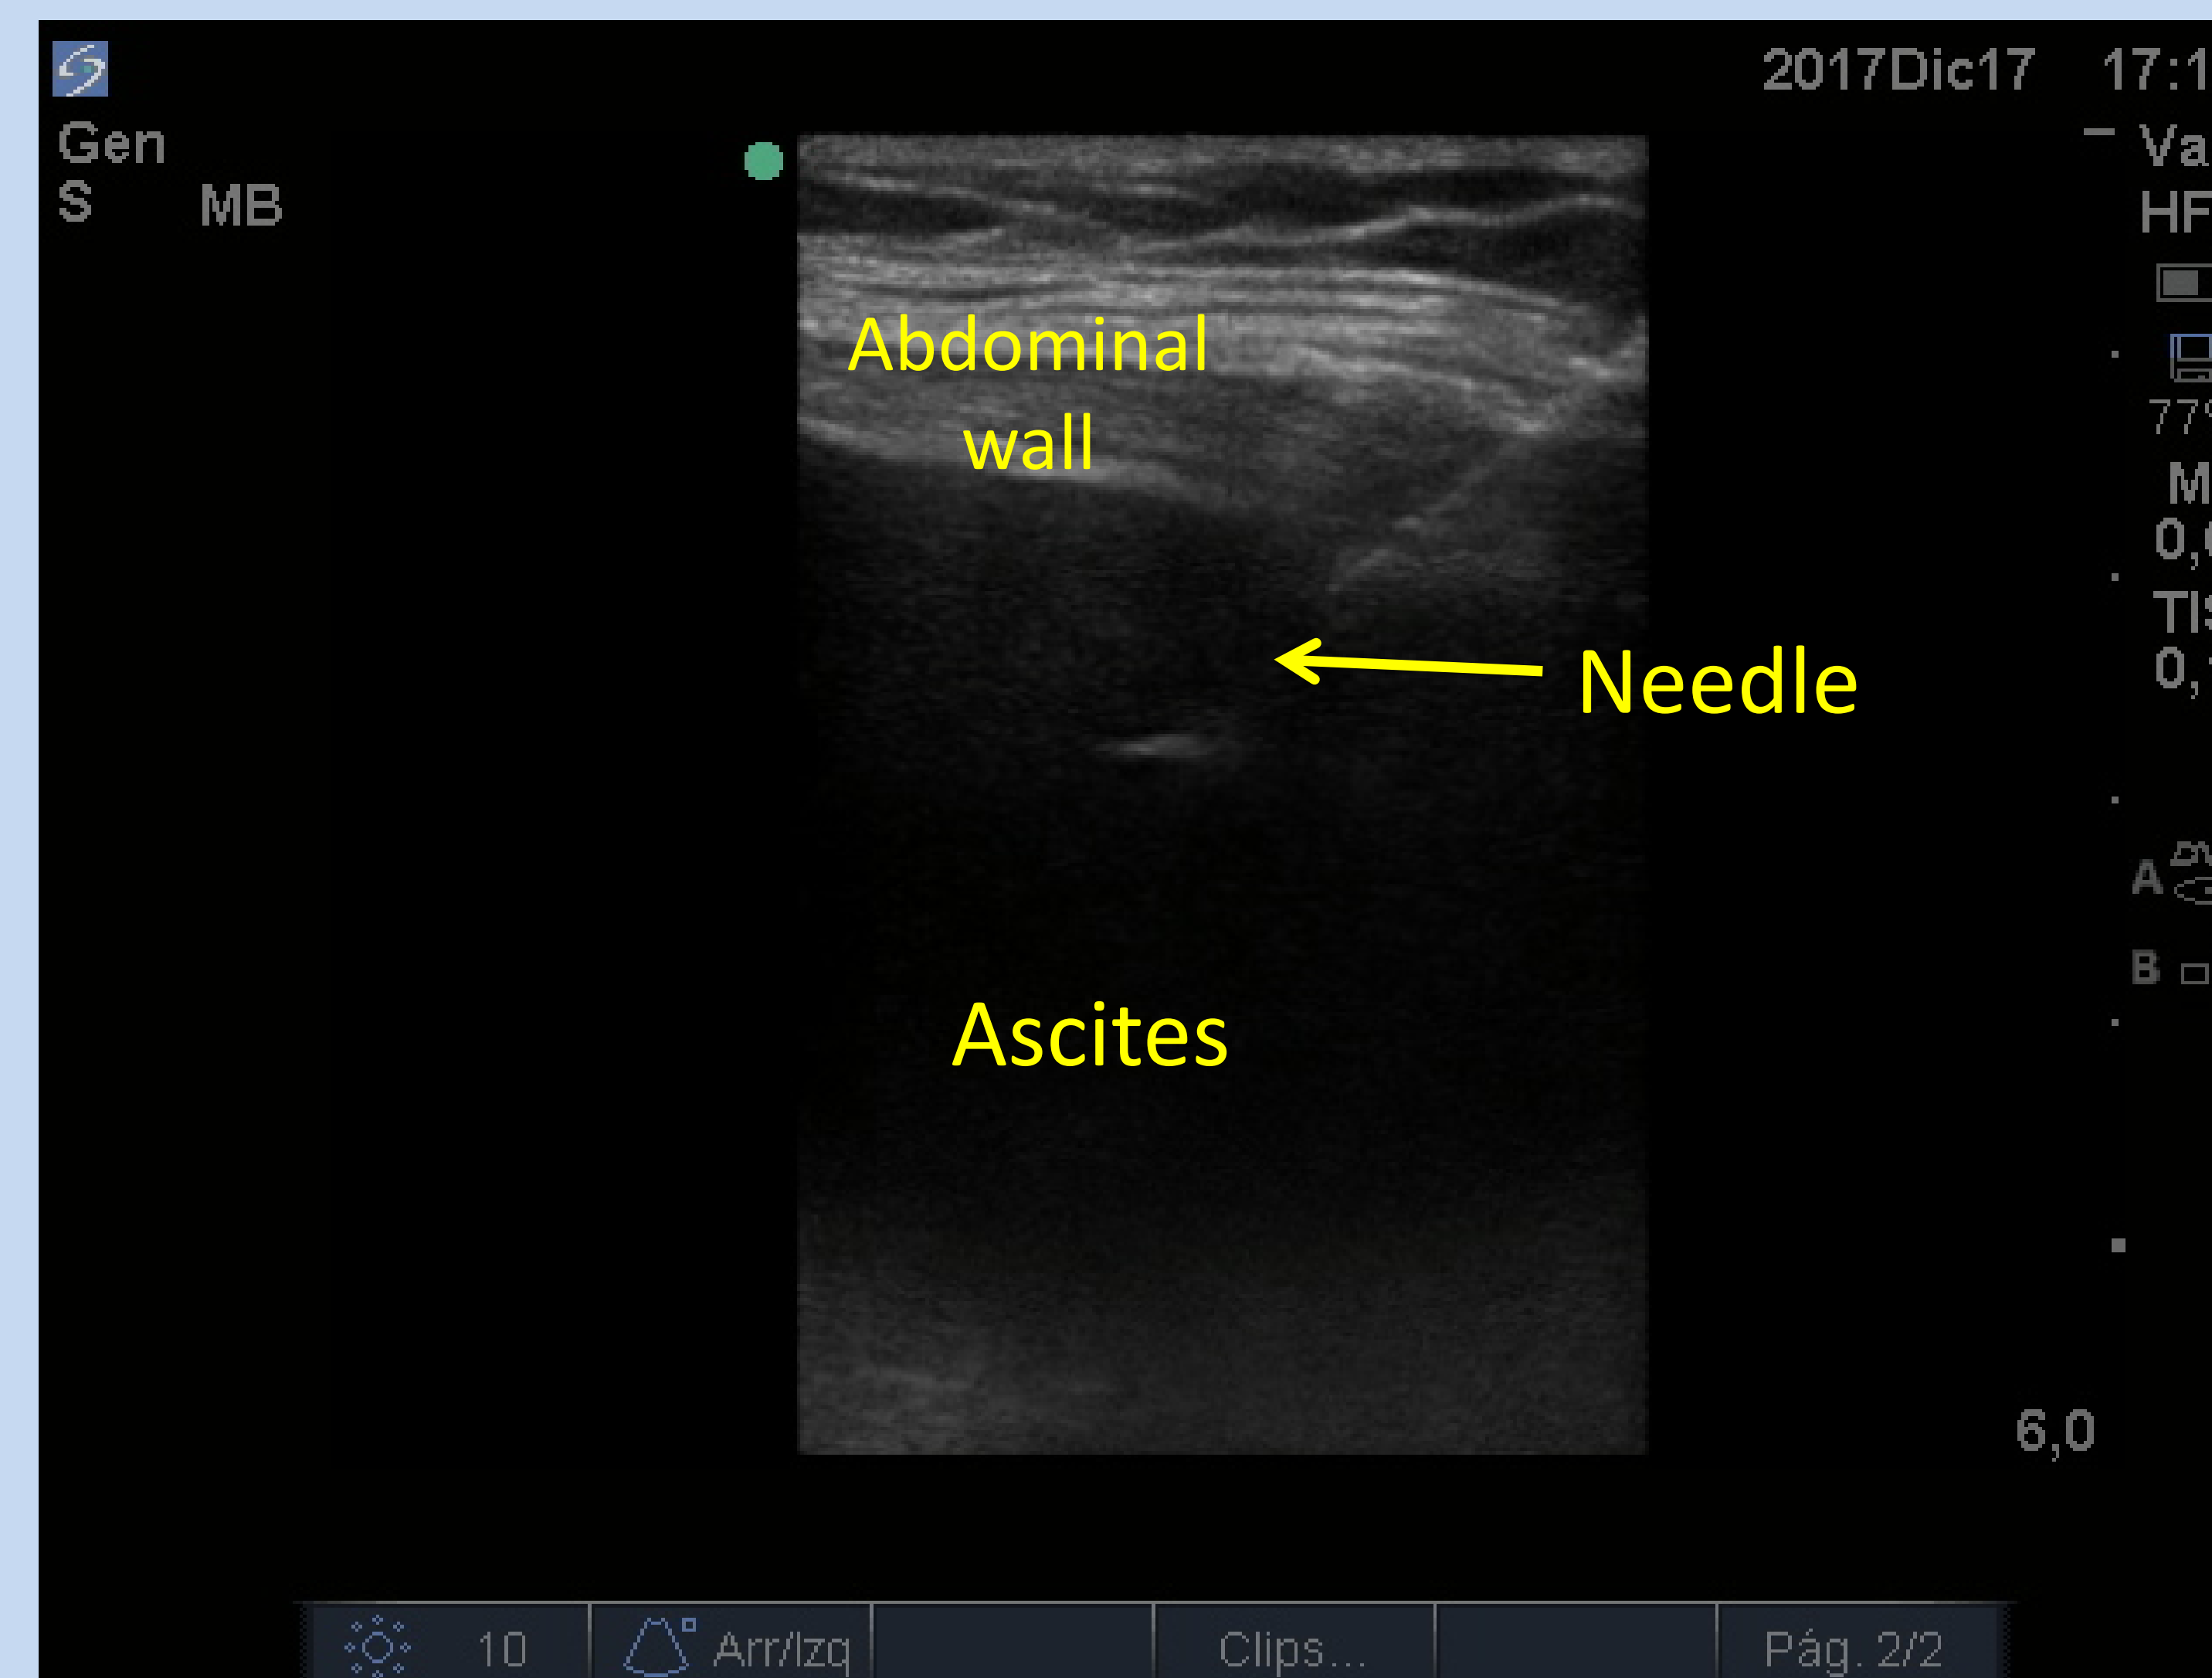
Ultrasound image of abdominal wall with the needle entering the peritoneal cavity.
